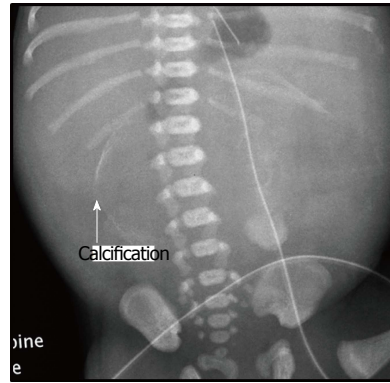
Plain abdominal radiograph showing eggshell calcification compatible with cystic meconium peritonitis.
